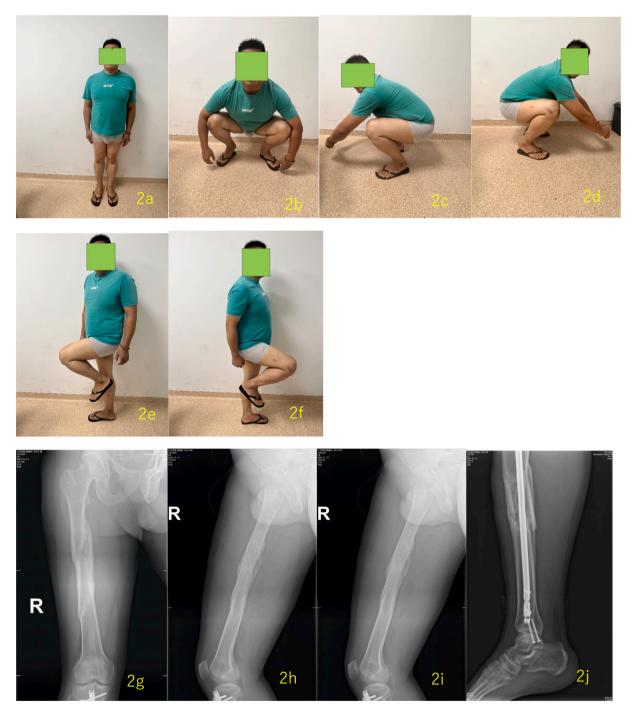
a-f. 3 years postoperations follow-up show good function of right hip and knee joint. g-j. X-ray of 3 years postoperations showed good union of ipsilateral comminuted femoral shaft and tibial shaft fracture of right side.
